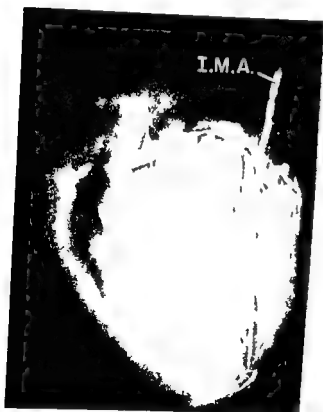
In mortem radiograph of heart taken after injection of contrast material into the internal mammary artery (I.M.A.) implanted into left ventricle. The lumen of the implanted artery is severely narrowed near the left ventricular apex. The left coronary artery is opacified by retrograde filling from the implanted internal mammary artery.
